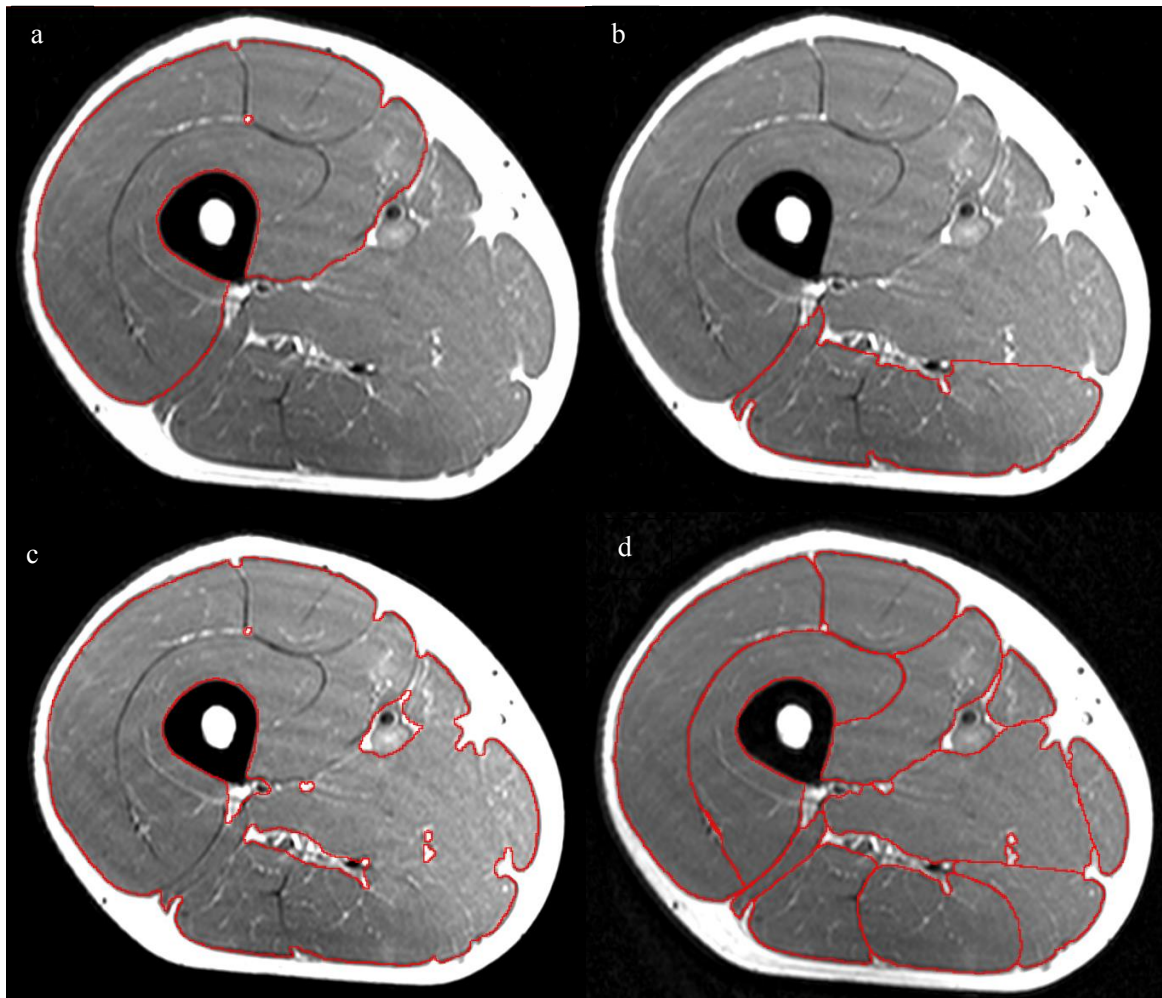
Representative MR images in the middle of the upper leg with delineations of; a) *M. quadriceps* muscle, b) *M. hamstrings* muscle, c) thigh muscle and d) 11 individual muscles.
